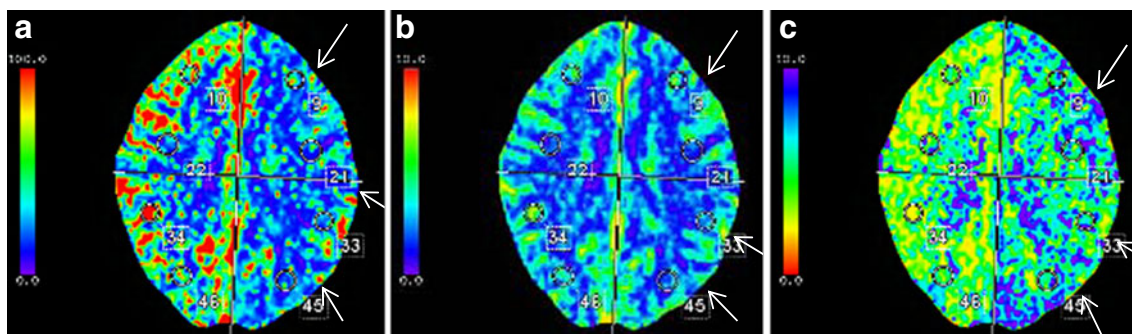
CT perfusion during aura. a CBF, b CBV, and c MTT maps reveal abnormally reduced CBF, normal CBV, and increased MTT throughout the entire left cerebral hemisphere, respectively. Findings are consistent with hypoperfusion
